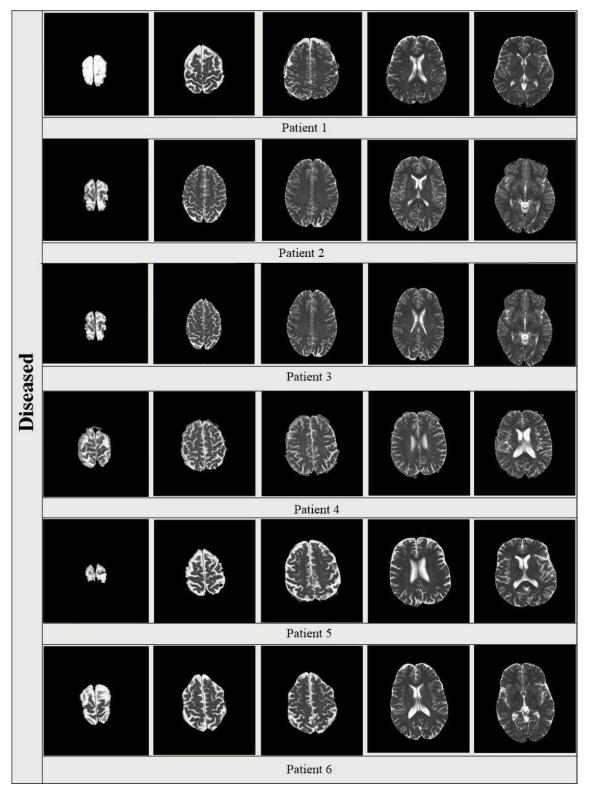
Samples of six patient segmented MRI scans of the diseased dataset.
